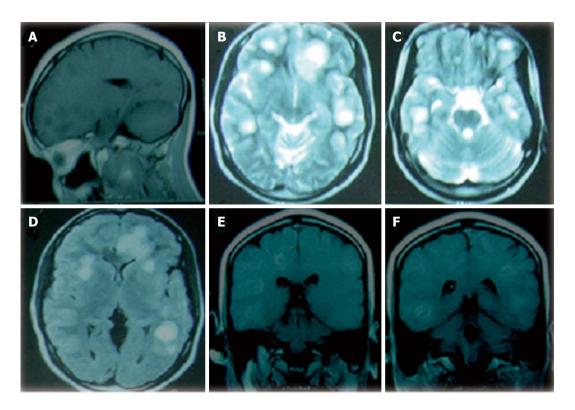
Cranial magnetic resonance imaging brain (on admission) showing (A) sagittal T1-weighted view with multiple hypointense lesions in the frontal and parietal regions, (B, C) axial T2-weighted images showing multifocal large hyperintense lesions in the frontal, parietal, temporal and occipital lobes, (D) axial fluid-attenuated inversion recovery-weighted image showing hyperintense lesions with minimal perifocal hypointense rim (edema), (E, F) coronal T1-weighted contrast enhanced views with patchy enhancement of the hypodense lesions in the temporal, parietal and frontal lobes bilaterally.
